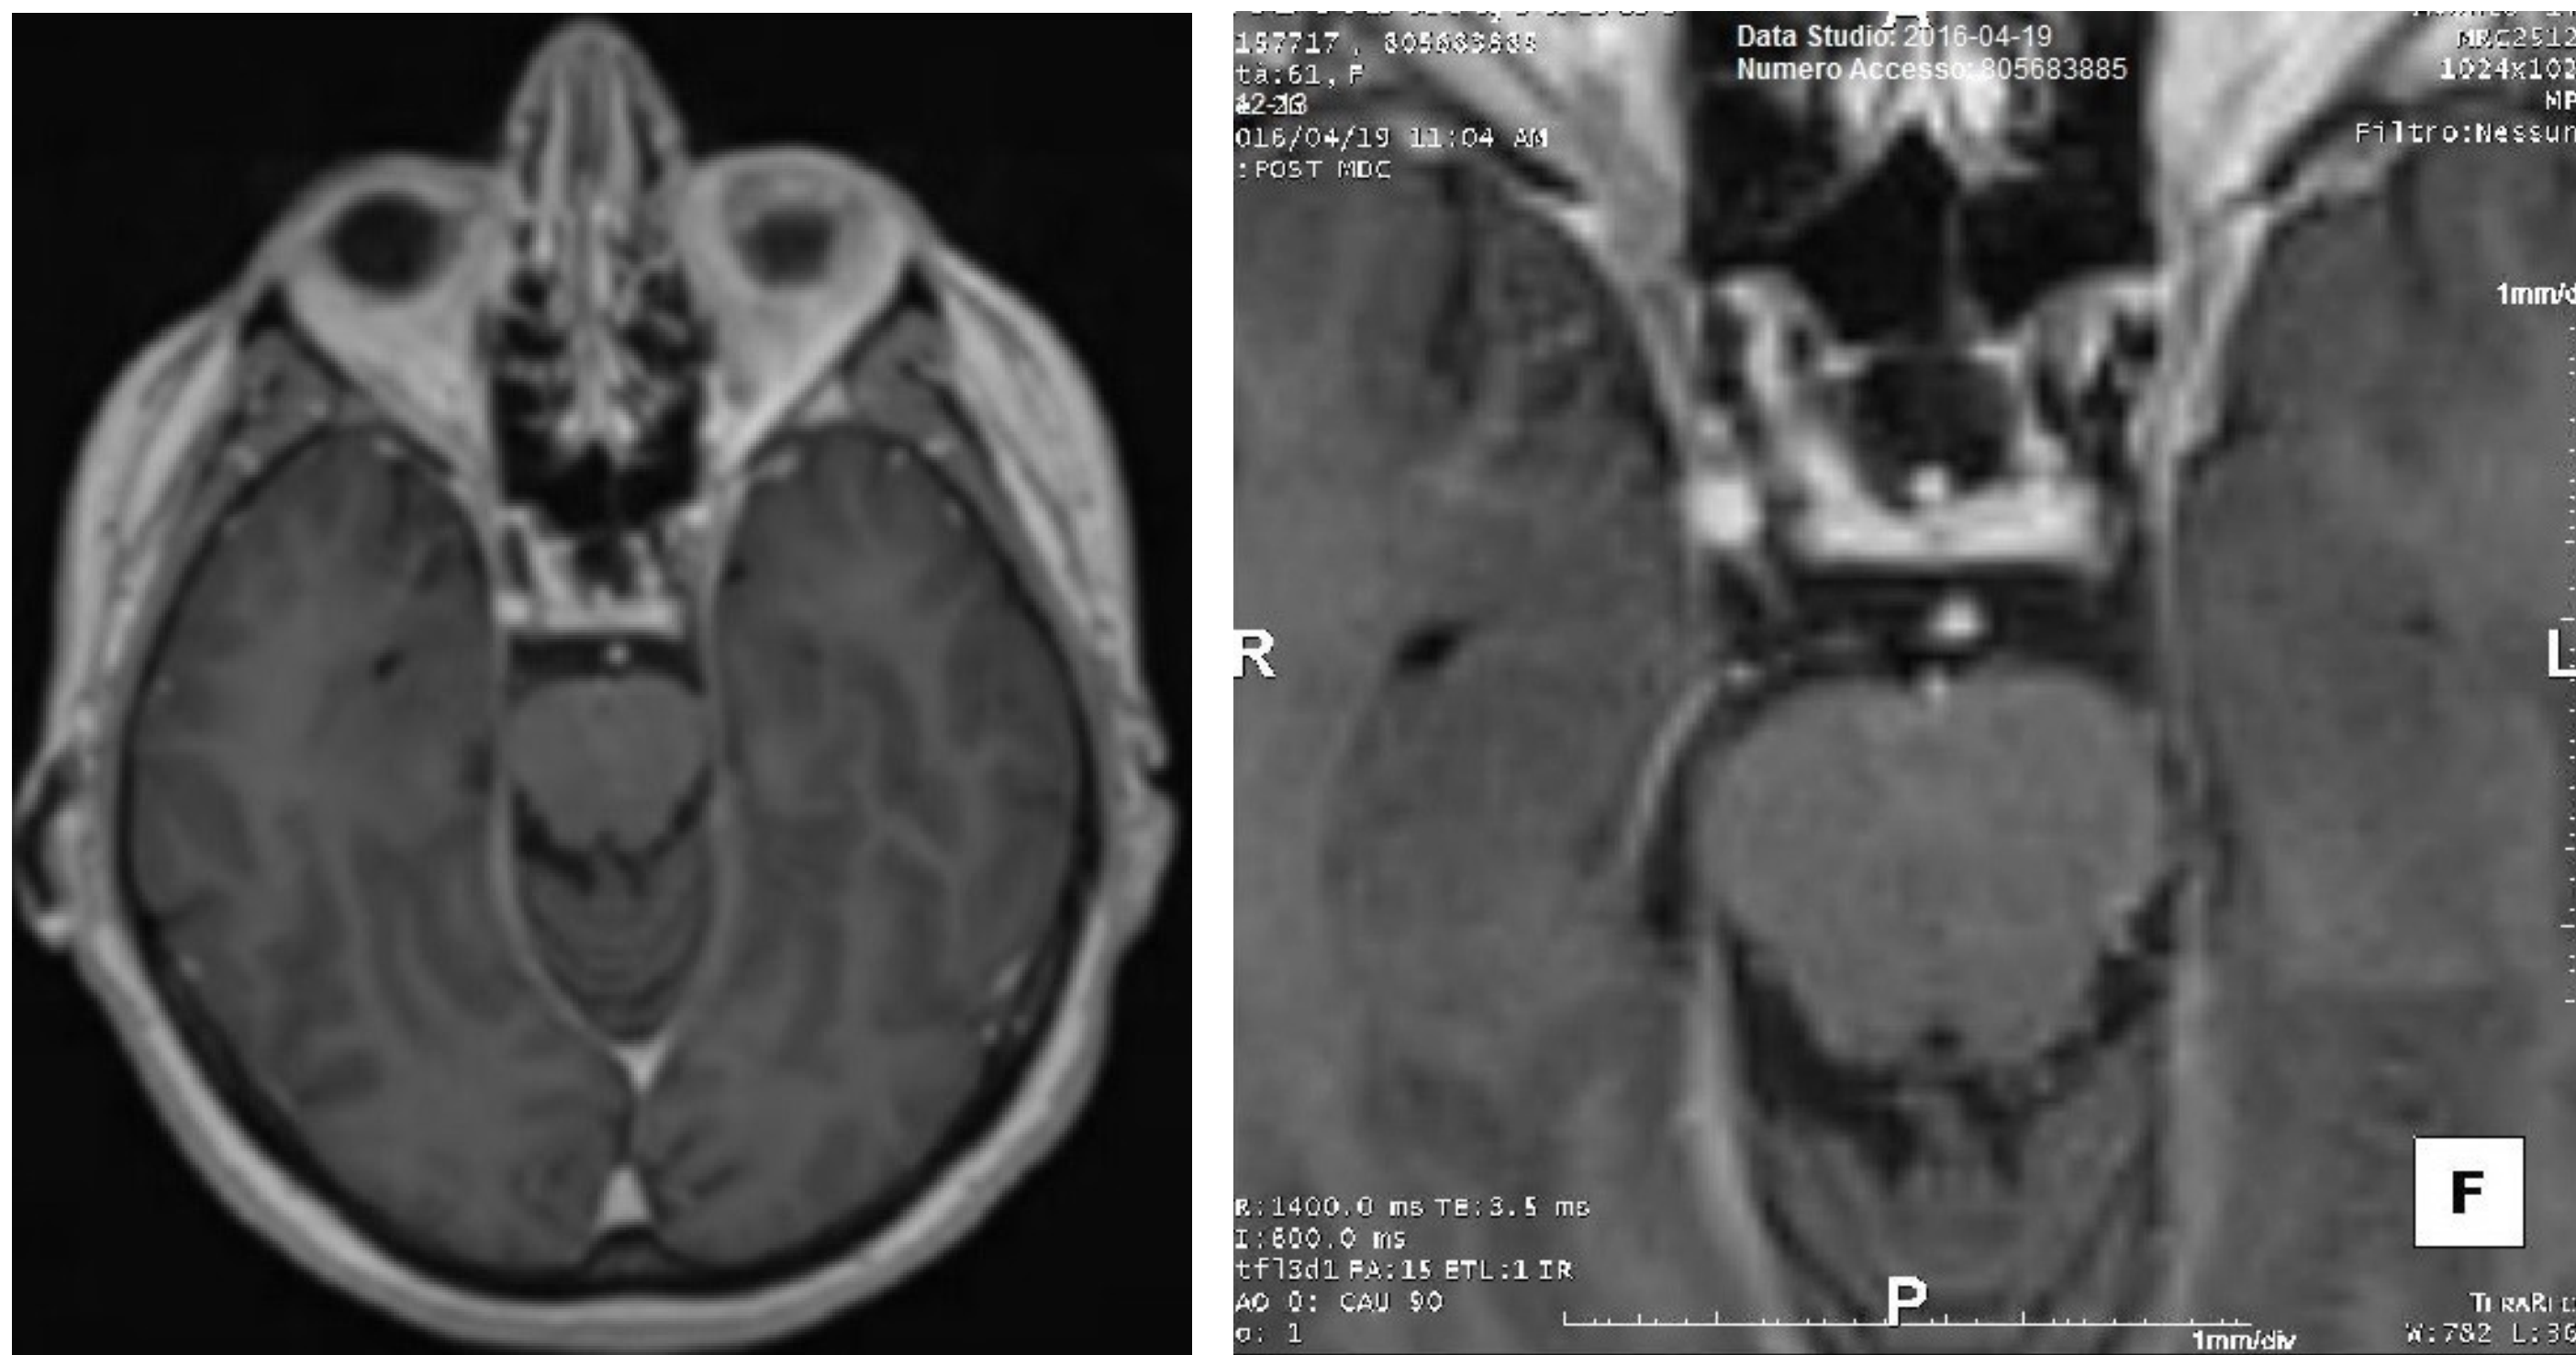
Gadolinium-enhanced T1-weighted axial MRI showing an ovoid small lesion of the right third cranial nerve in the cavernous sinus.
